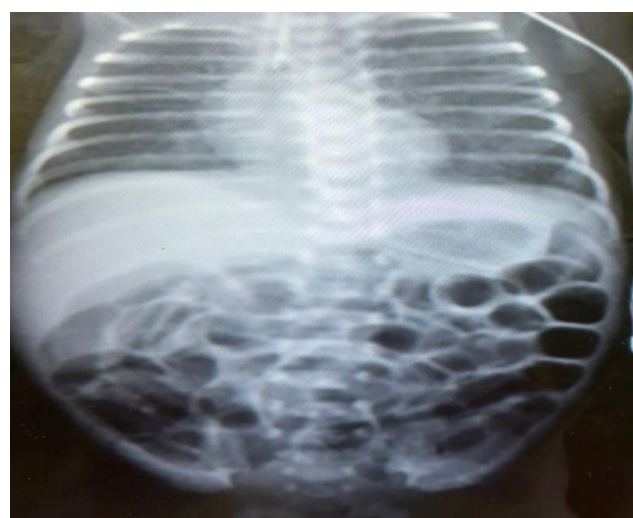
Supine chest and abdominal radiograph.
